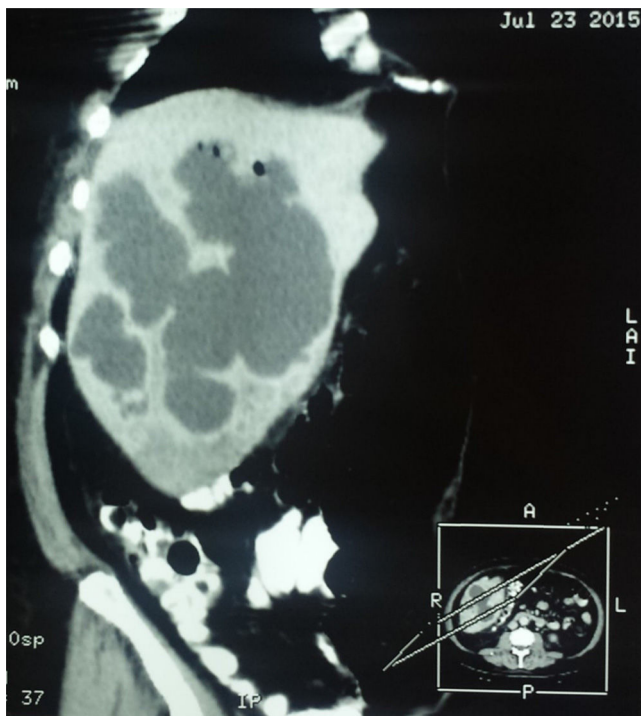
Oblique sagittal view of a double-contrast computed tomography scan showing cystic lesions, corresponding to amoebic liver abscesses.
